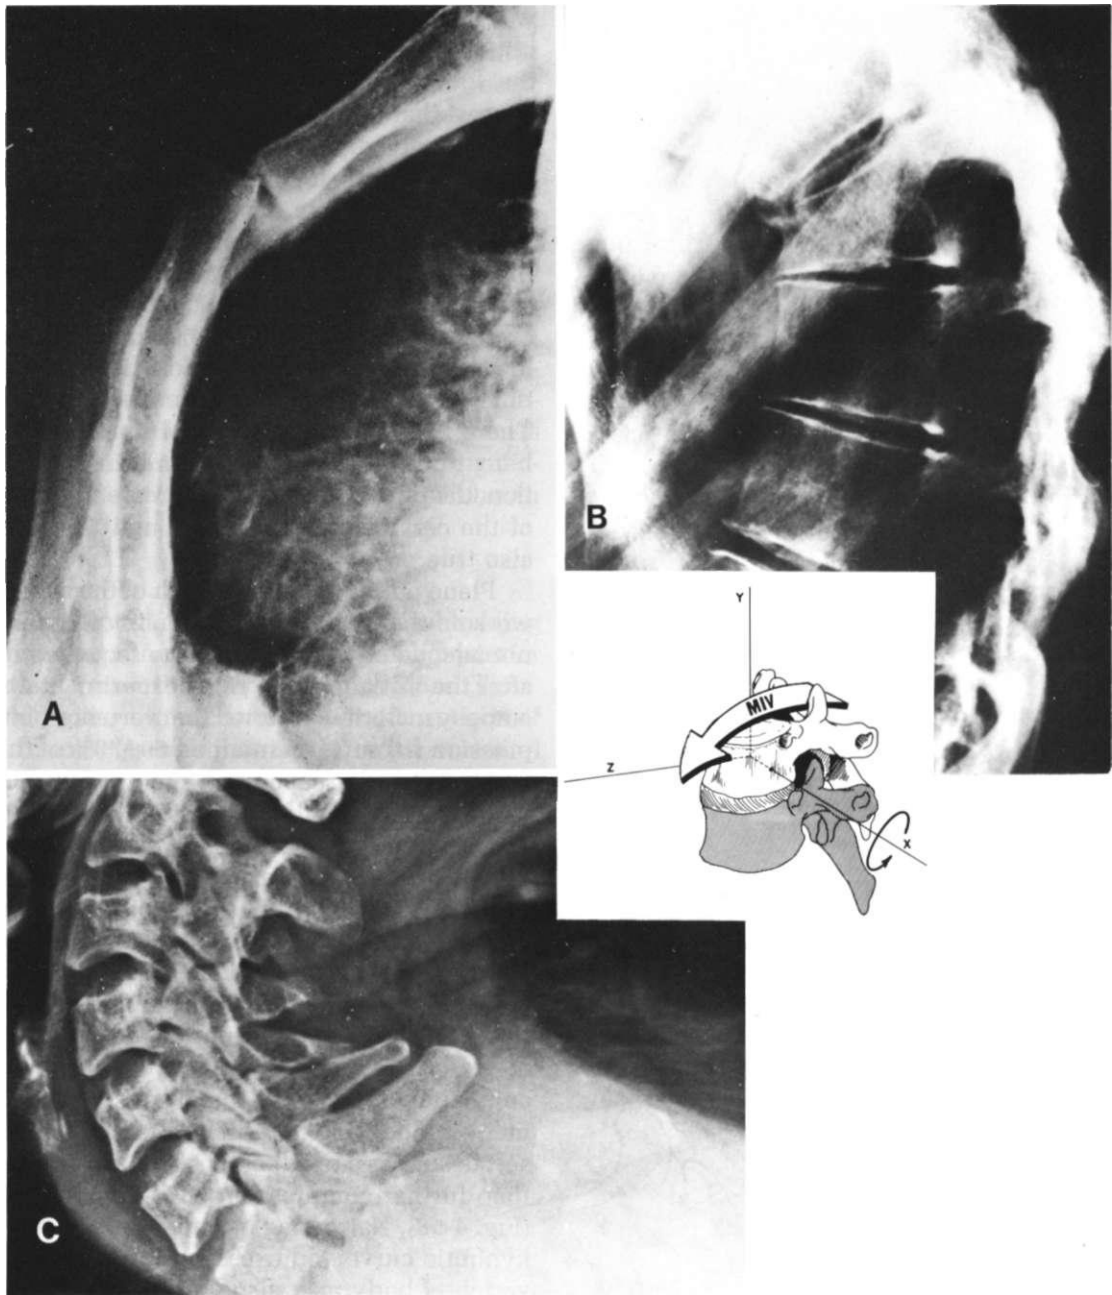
Lateral radiograph of the sternum. (A) There is a fracture dislocation of the manubriosternal joint. The patient also had a pneumothorax associated with a fracture of the second rib. (B) Lateral radiograph of the dorsolumbar spine shows wedge compression fractures of the fifth and sixth thoracic vertebrae, resulting in a 90° kyphosis. This is due to a large +x-axis bending moment. (C) A view of the cervicodorsal junction shows that the spinous processes of the three upper thoracic vertebrae have been completely avulsed. This is due to tensile loading associated with the MIV. Cervical lordosis is exaggerated because of the thoracic kyphosis. (Radiographs courtesy of Mr. T. McSweeney, The Robert Jones & Agnes Hunt Orthopaedic Hospital, Oswestry, U.K.)
